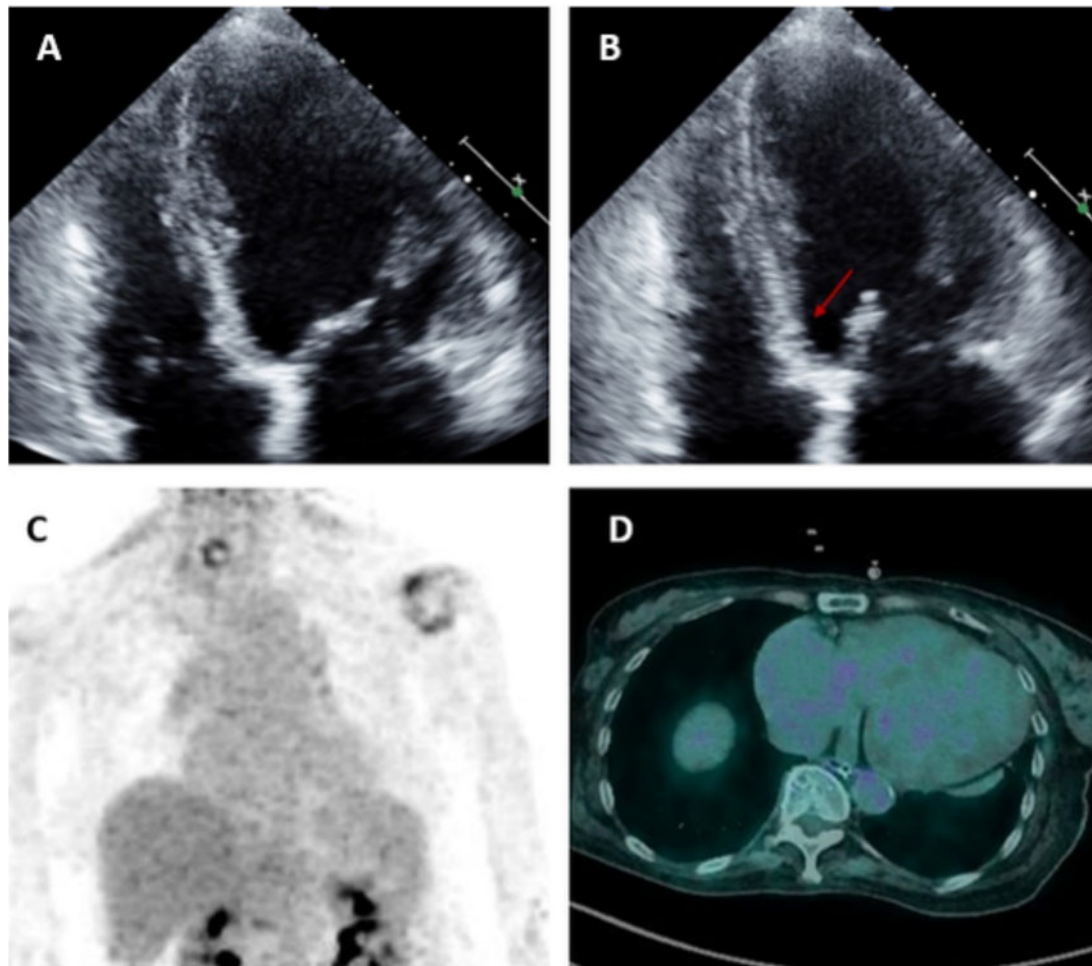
Findings of multimodality cardiac imaging studies. Echocardiograms taken 1 day after cardiac arrest in the apical four-chamber view of the end-diastole (A) and end-systole (B) showed a decreased LV ejection fraction of 37% with an akinetic basal septum (arrow) and dilated LV. Maximum-intensity projection image (C) and fused ^{18}F -FDG positron-emission tomography/computed tomography image (D) showed no abnormal FDG uptake in the LV myocardium. FDG, fluorodeoxyglucose; LV, left ventricular.
